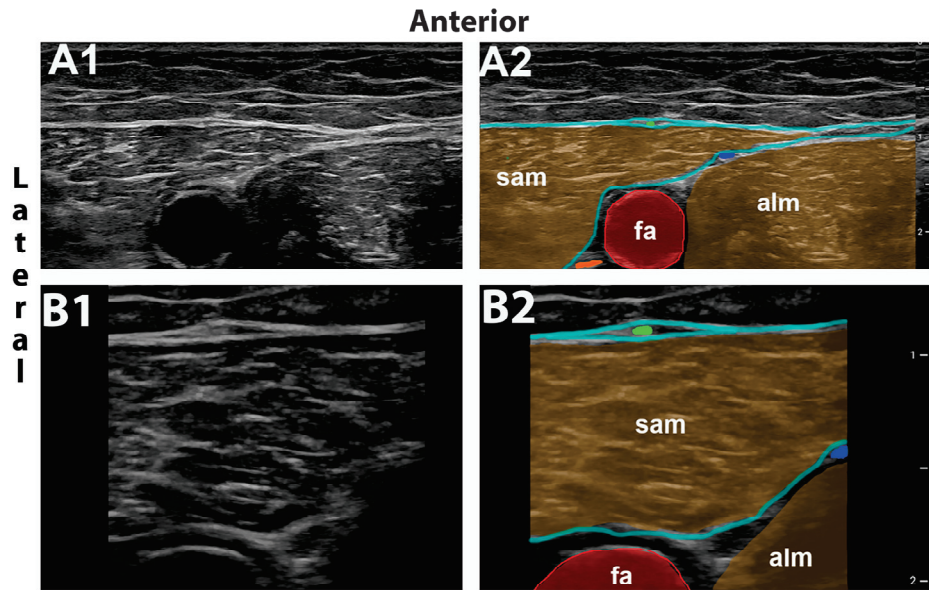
MFCN-A block used in volunteers. Ultrasound images showing the level of injection for the MFCN-A block without (A1) and with (A2) color overlay using 15 MHz. (B1) and (B2) is a 19 MHz image without and with color overlay corresponding to (A1) and (A2). MFCN-A (green dot) can be approached selectively in a duplicature of the fascia lata anterior to the sartorius muscle (sam). Adductor longus muscle, alm; posterior branch of medial femoral cutaneous nerve, blue dot; saphenous nerve, orange dot.
